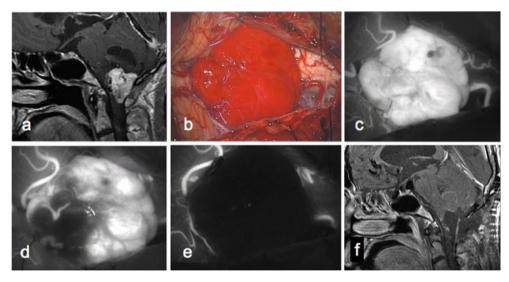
Sagittal enhanced MR image (a) demonstrating a solid tumor with a cyst in the dorsal medulla oblongata. Intraoperative photogram (b) showing a red tumor exposing the cisterna magna. Initial ICG-VA (c) showing blood flow in the tumor and surrounding vessels. After occlusion of feeders from the bilateral
